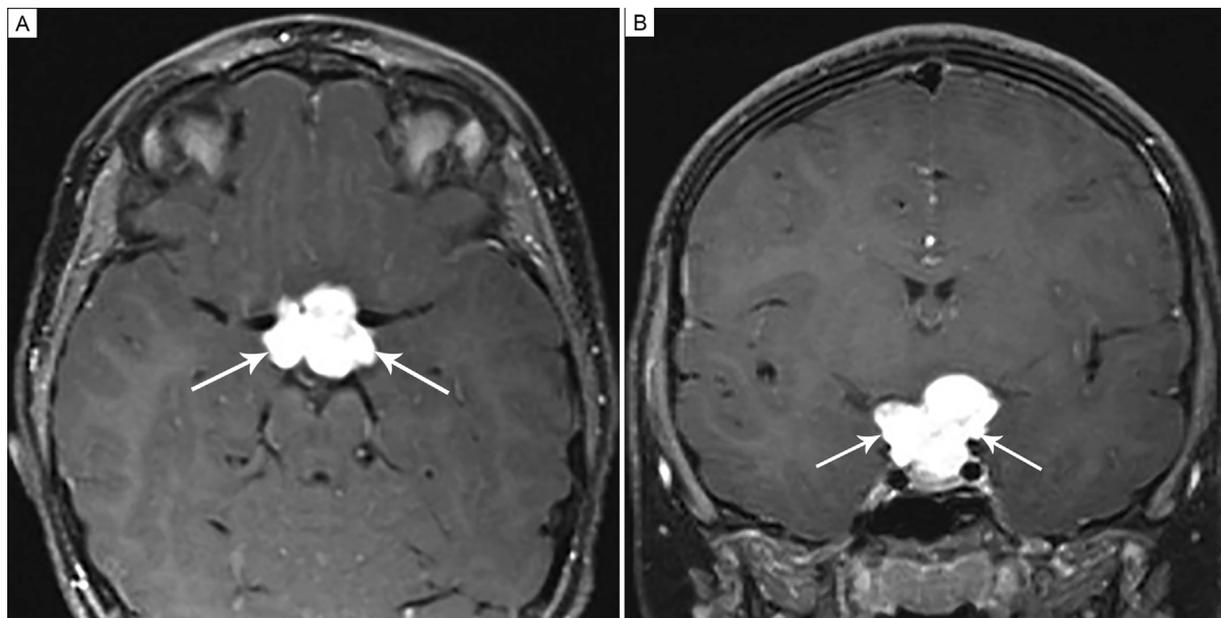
Gadolinium-enhanced T1-weighted magnetic resonance imaging (A, axial; B, coronal) showing chiasmal glioma with superior extension on the left side: the arrows denote the lateral margin of the tumor.
